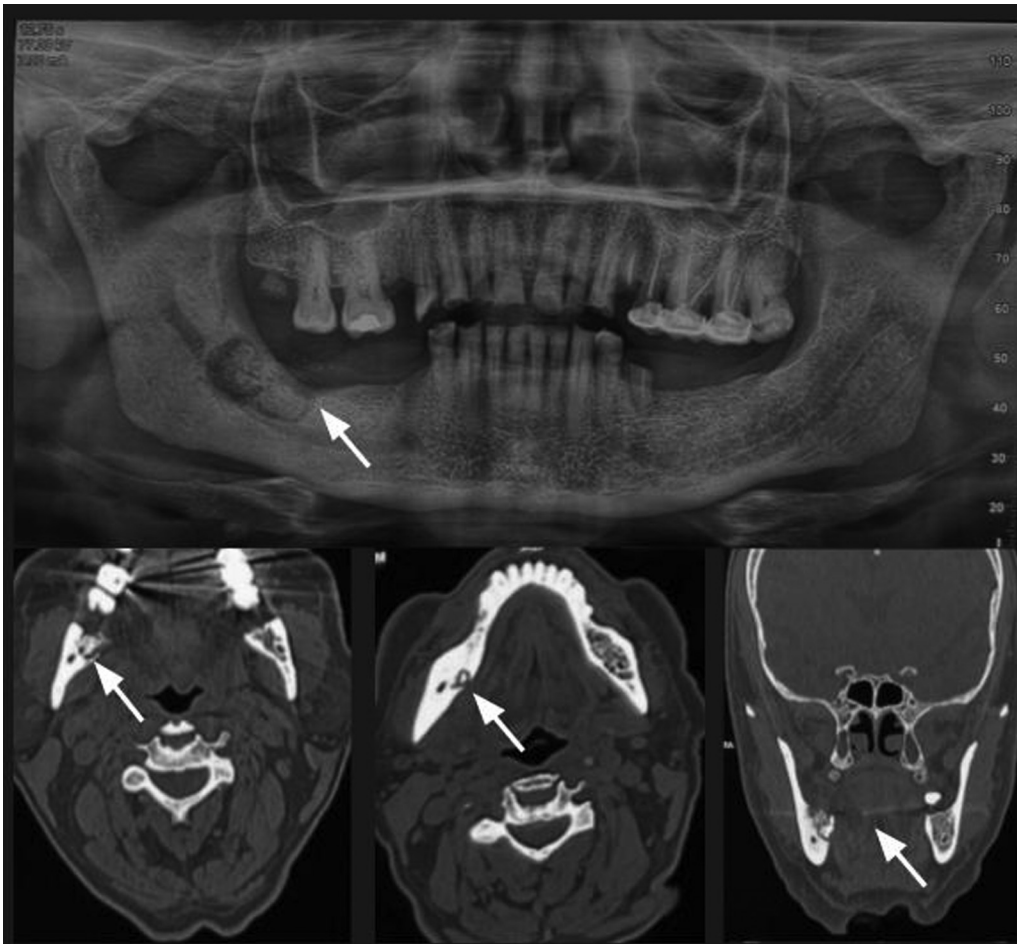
Medication-related osteonecrosis of the jaw secondary to bisphosphonate. A 68-year-old male patient with multiple myeloma and a treatment history of zoledronic acid 25 mg/day for 2 years. Orthopantomogram (OPG) and computed tomography (CT) images show a well-defined lytic lesion in the body of the right hemimandible with a central sequestrum and generalized sclerosis of the right hemimandible (arrows). No periosteal new bone formation s/o medication-related osteonecrosis of the jaws (MRONJ).
